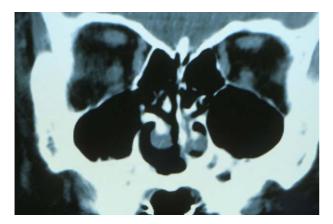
A preoperative coronal computed tomography scan revealed a midline cystic lesion of the maxilla.
